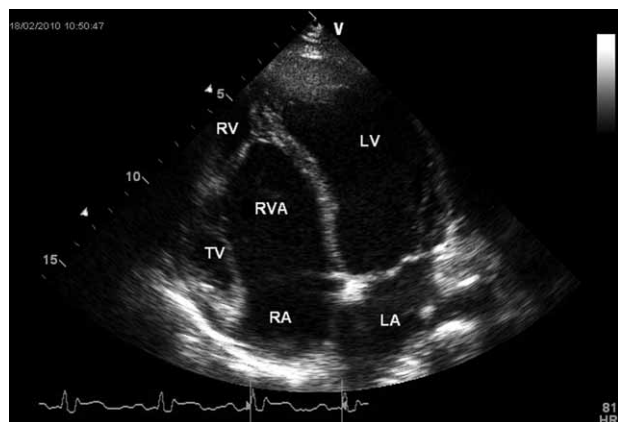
Example of an echocardiogram (apical 4-chamber view) of a patient with Ebstein's anomaly. The functional RV is small, replaced by the large RVA. RV – right ventricle; RVA – atrialized right ventricle; TV – tricuspid valve; LA – left atrium; LV – left ventricle; RA – right atrium.
